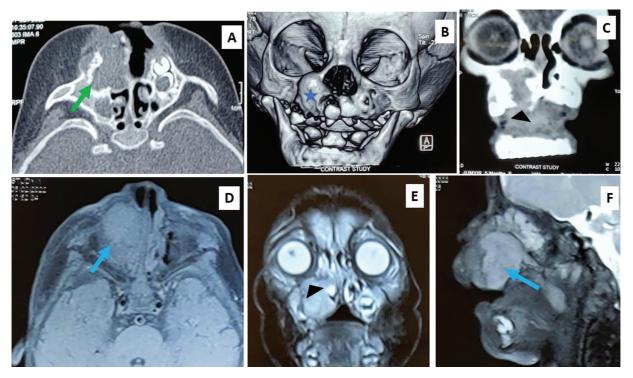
(A) Axial section computed tomography (CT) scan demonstrates tumor obliterating right maxillary sinus (green arrow). (B) Three-dimensional (3D) reconstructed computed tomography scan shows the extent of the tumor (blue star). (C) Coronal section CT scan causing erosion of right hard palate (black arrowhead). (D) T1-weighted axial section magnetic resonance imaging (MRI) scan demonstrating the tumor obliterating the right nasal cavity (blue arrow). (E) T2-weighted coronal section MRI scan showing tumor abutting the right orbit (black arrowhead). (F) Sagittal section T2-weighted MRI scan shows lobulated tumor (blue arrow).
